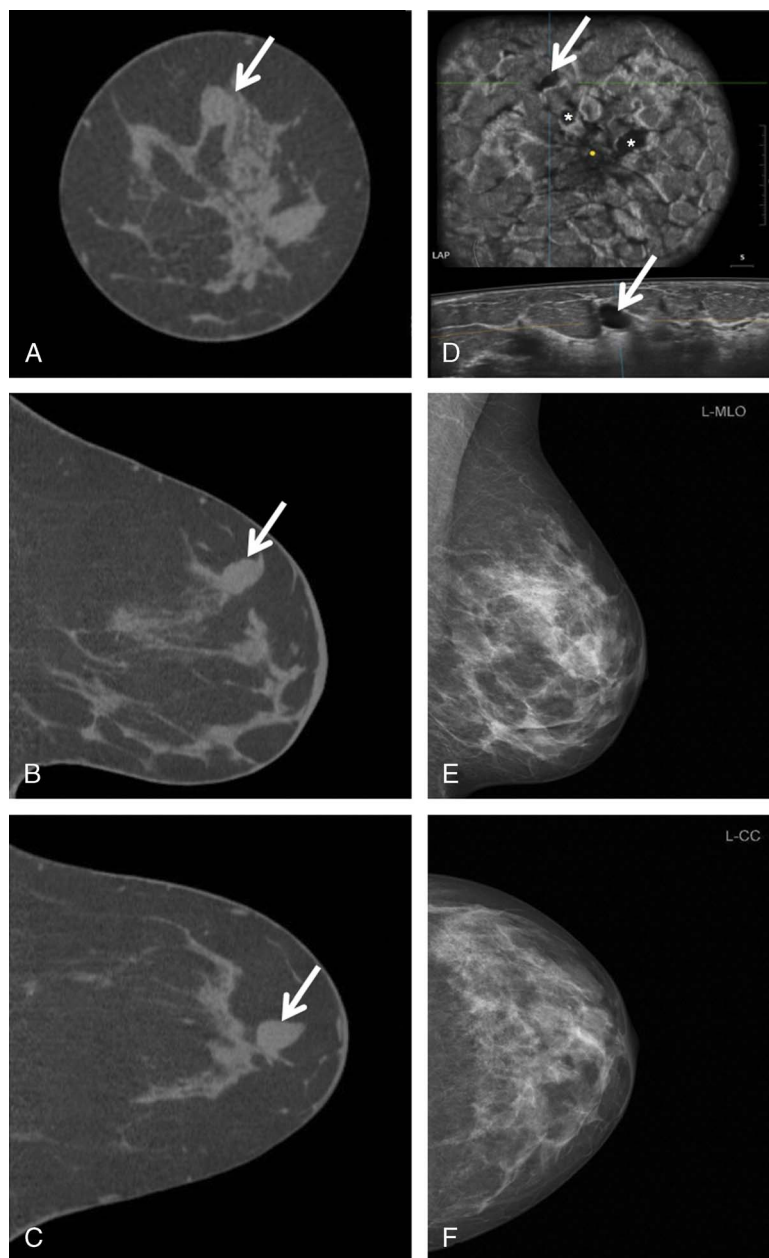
Oval circumscribed lesion at 11 to 12 o'clock in the left breast of a 51-year-old woman. The lesion can be easily depicted in the coronal, sagittal, and axial B-CT ST (A–C). The corresponding lesion in coronal and axial ABUS images (D) was a cyst with a maximum diameter of 11 mm that was stable compared with a previous sonographic examination performed 18 months before B-CT. Two additional cysts can be recognized in the coronal ABUS image at 11 and 2 o'clock closer to the nipple (marked with asterisk). Although we consider that some breast density changes could be occurred in the time interval, in mammography (E and F) performed 18 months before B-CT, the cyst was not clearly identifiable.
